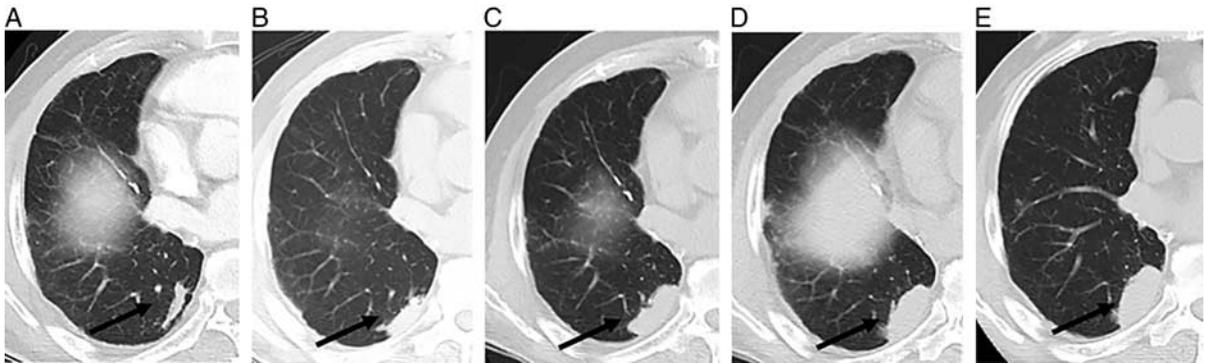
Slow progression of a metastatic NSCLC lung cancer lesion (arrow) in a patient receiving TKI therapy (Erlotinib). A, Baseline axial CT image of right lower lobe NSCLC before commencing TKI therapy with subsequent slow growth over 32 months on TKI therapy. B, CT 6 months after TKI therapy. C, CT 16 months after TKI therapy. D, CT 24 months after TKI therapy. E, CT 32 months after TKI therapy.
